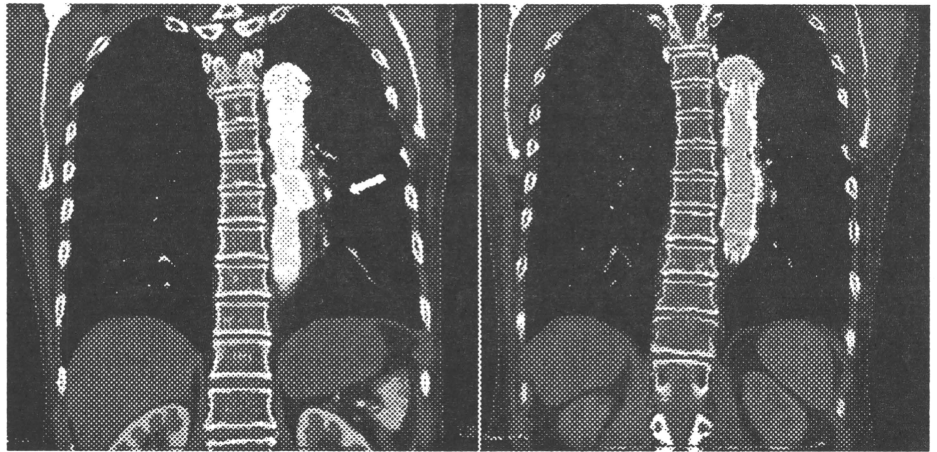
Left* Enhanced CT revealed that the distal edge of the stent-graft was protruding from the descending aorta (white arrow) and was located distal to the site of anastomosis of prior graft replacement. *Right* At 6 months after the operation, enhanced CT showed that the distal anastomotic pseudoaneurysm was obliterated
